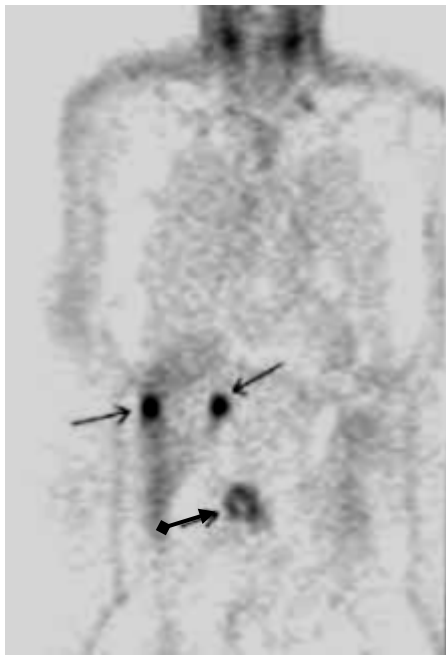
PET imaging. Coronal FDG-PET (fluorodeoxyglucose) slice at level of the pancreas head. The pancreas head tumour (arrow with rhombus) and two metastasises in the liver (arrows) [28]
